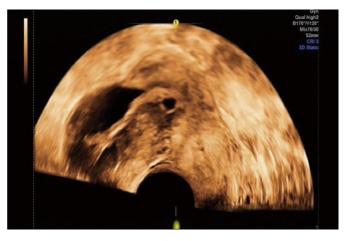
Transvaginal ultrasound image showing right hydrosalpinx begun at the uterine corner and a small no echo zone in intrauterine cavity.
